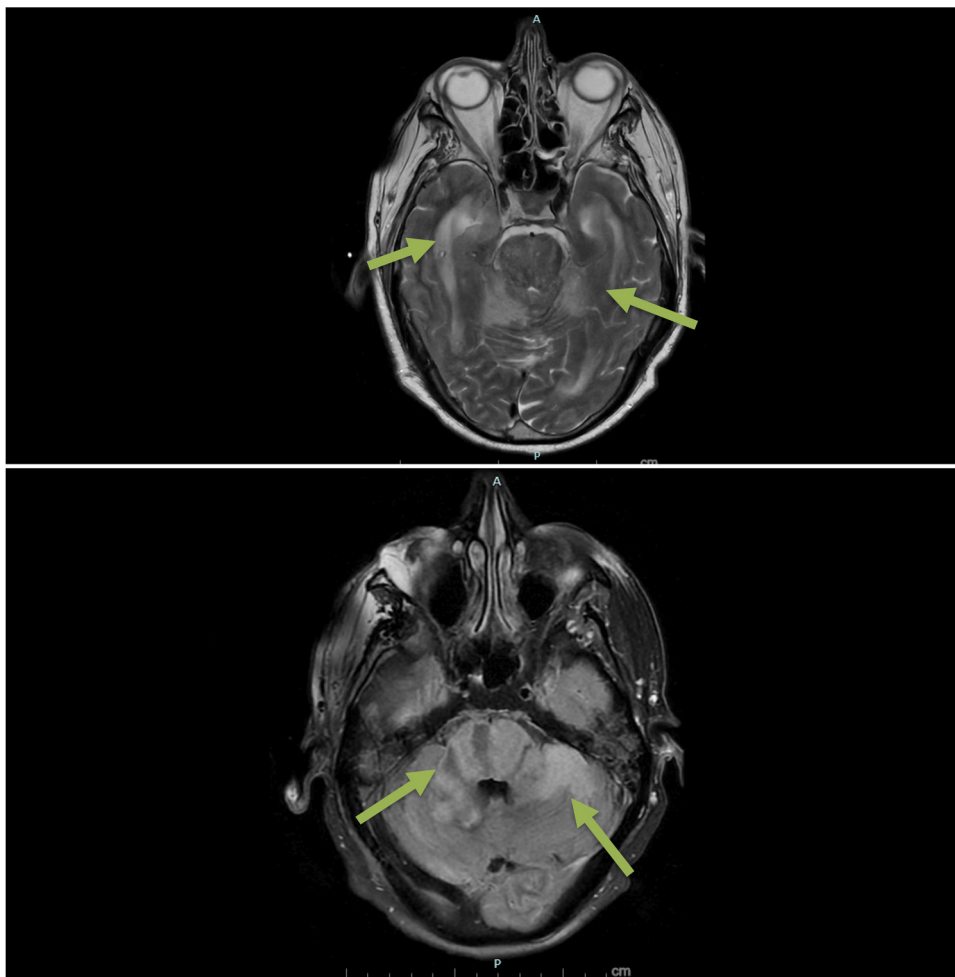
T2 a brain MRI with and without contrast revealing extensive restricted diffusion.
